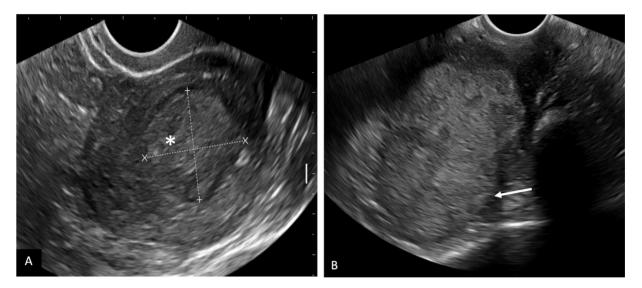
Transvaginal ultrasound in carcinoma endometrium. A: A large relatively well-defined iso to hyperechoic mass lesion (\*) in the endometrial cavity with < 50% myometrial invasion. B: An ill-defined hyperechoic mass in the endometrial cavity with > 50% invasion into myometrium (arrow).
